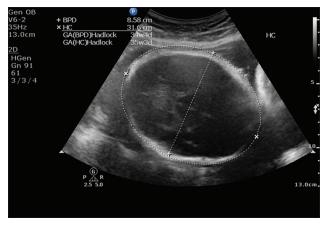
Ultrasonographic image of head circumference of 34 weeks gestation
